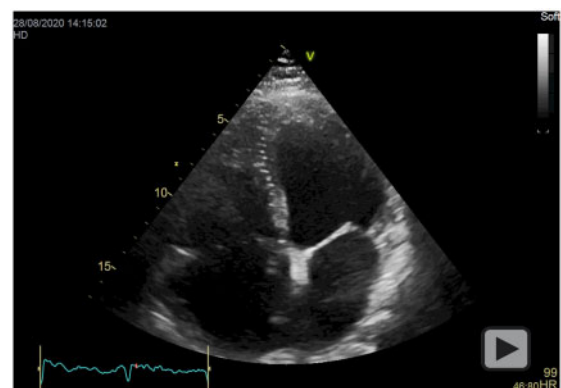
(A) Parasternal long axis of the heart demonstrating a right ventricular thrombus attached to the tricuspid valve and severe left ventricular impairment; (B) Apical four-chamber view of the heart demonstrating a 3 cm long right ventricular thrombus attached to the tricuspid valve, enlarged right ventricle with impairment and deviation of the interventricular septum towards the left ventricle; (C) Apical four-chamber view focused on the right ventricle. This view shows a much clearer outline of the elongated tricuspid valve thrombus; (D) Day 6 after admission: Parasternal long-axis view of the heart showing the disappearance of the right ventricular thrombus.
